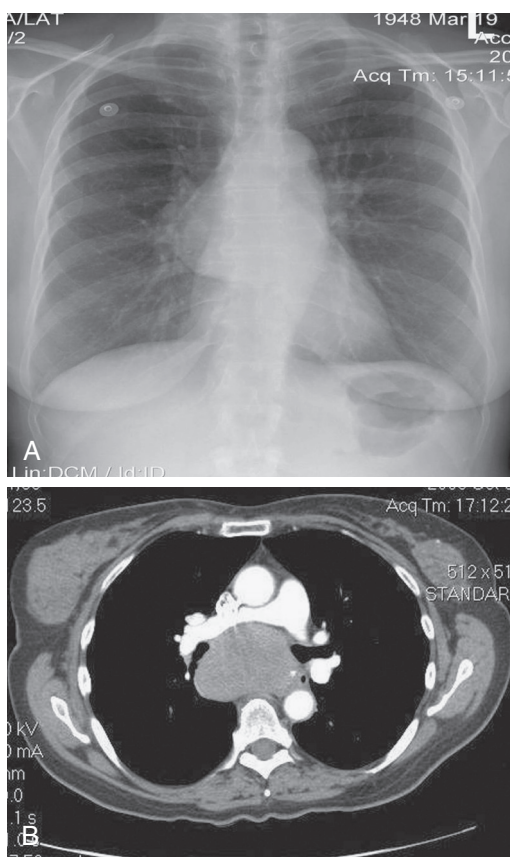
■ A, Posteroanterior chest radiograph of a 55-year-old woman with chest heaviness and mild dysphagia to solids. A large middle mediastinal mass is noted. B, Computed tomographic scan demonstrates a subcarinal mass. Differential diagnosis includes adenopathy (lymphoma) and bronchogenic or esophageal duplication cyst. Resection revealed a plasmacytoma.
